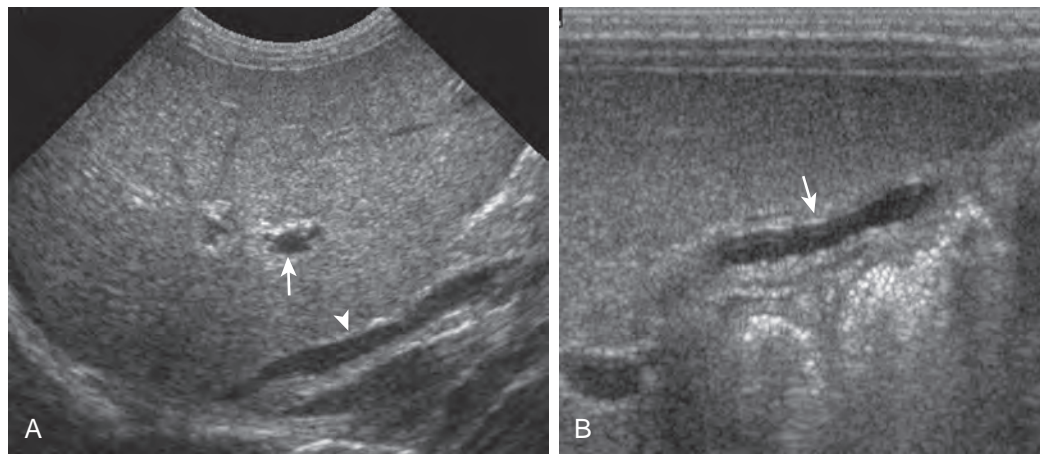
Biliary atresia: sonographic features. A. Longitudinal sonogram of a 22-day-old girl with cholestatic jaundice. The liver has a normal, uniform echotexture. The intrahepatic inferior vena cava (arrowhead), hepatic veins, and portal veins (arrow) are seen, but bile ducts are not identified. B. A small gallbladder (arrow) with an irregular wall is identified. There is no bile duct dilation. Biliary atresia was confirmed with nuclear scintigraphy, liver biopsy, and intraoperative cholangiography before treatment with a Kasai procedure.
